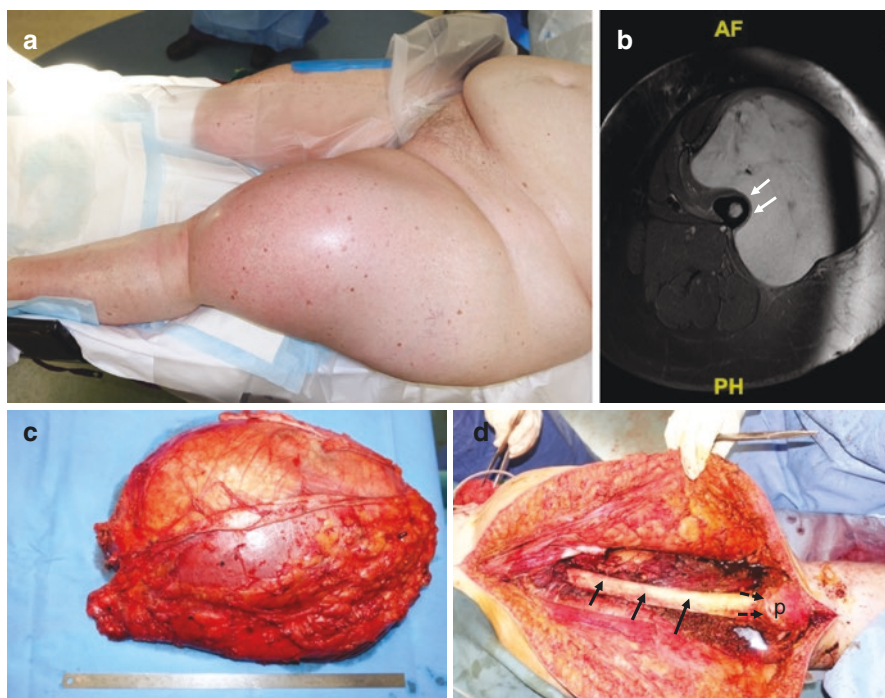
(a) Massive left quadriceps sarcoma. (b) T2-weighted fat suppressed axial MRI image of a myxoid liposarcoma involving almost the whole quadriceps muscle. Note the close proximity to the femur (arrows) (c) Quadriceps resection from origin to insertion into patella. (d) Femoral shaft on view denuded of periosteum which is the deep margin of the resection (solid arrows). Note patella (P) with resection ending at the quadriceps tendon insertion into the patella (dashed arrows)
